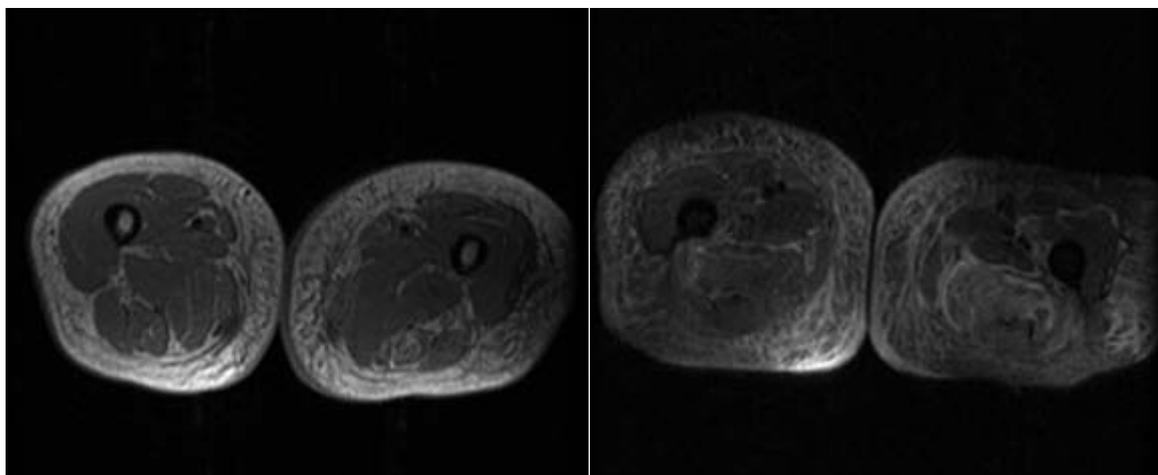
Coronal MRI of left thigh demonstrating swelling of adductor magnus and partial loss of normal intermuscular septa with isointense signal on T1 (A) and hyperintense signal on FSEIR (B) sequences.
